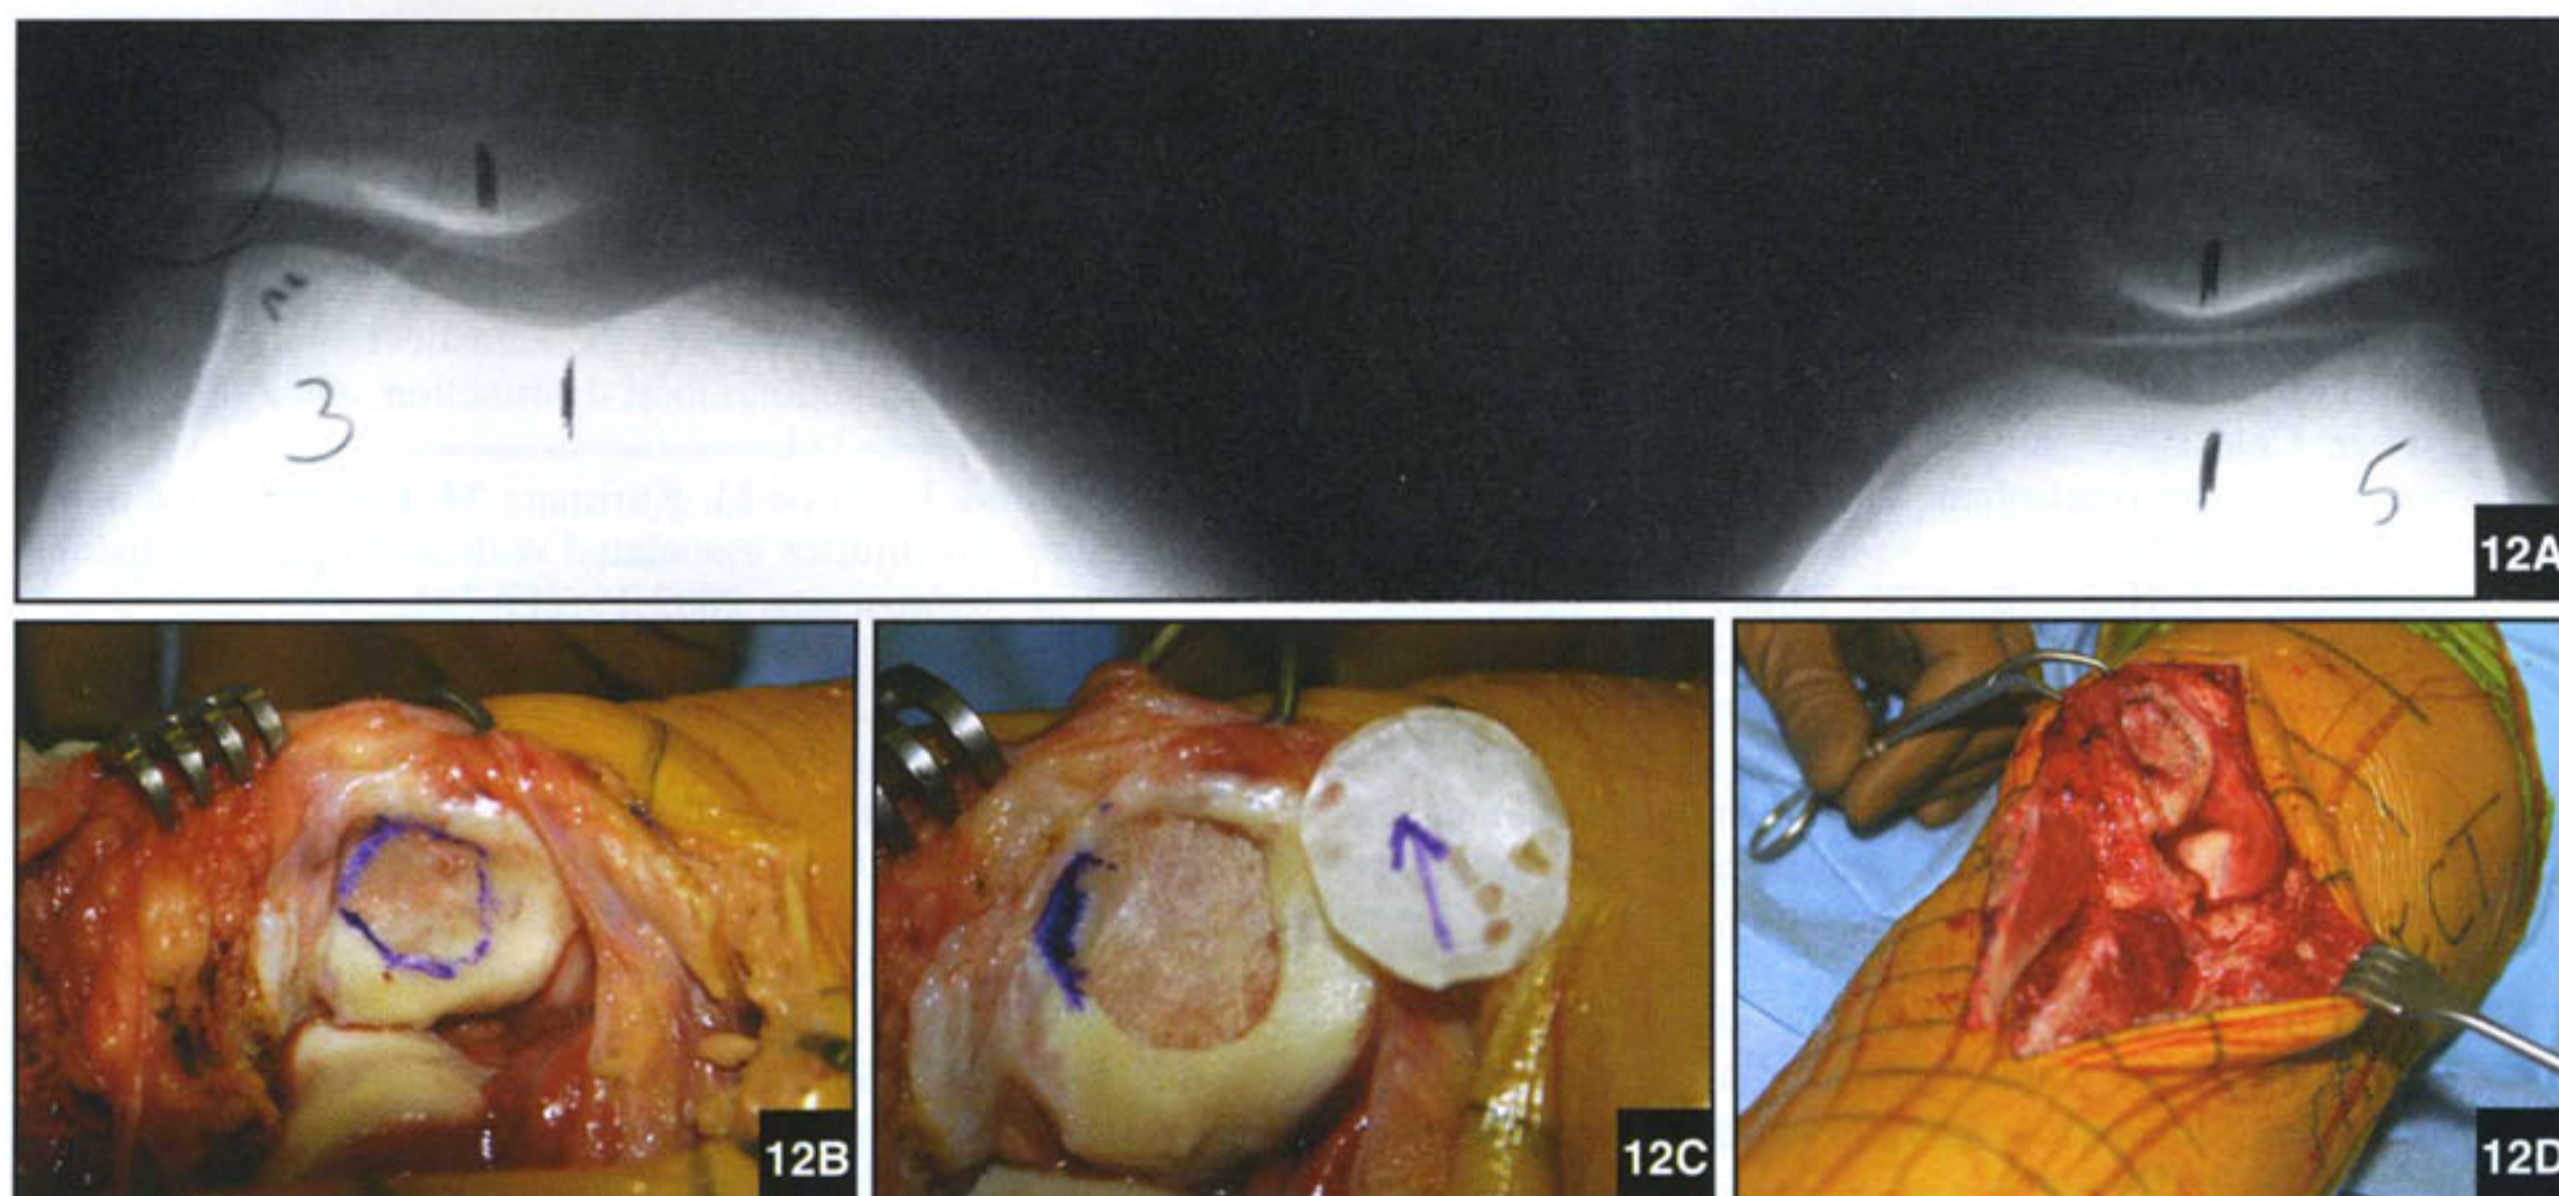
Merchant radiograph demonstrates chronic static patellar subluxation with mild patellofemoral lateral joint space narrowing (A). In a left knee, outline of diffuse midwaist centerolateral ICRS grade 3a, 3b, 3c chondrosis uncontained distal laterally (B). Debrided lesion with marked region of non-containment (C). Anteromedialization slope shown with completed autologous cultured chondrocyte implantation (slope will unload lateral lesion) (D).
